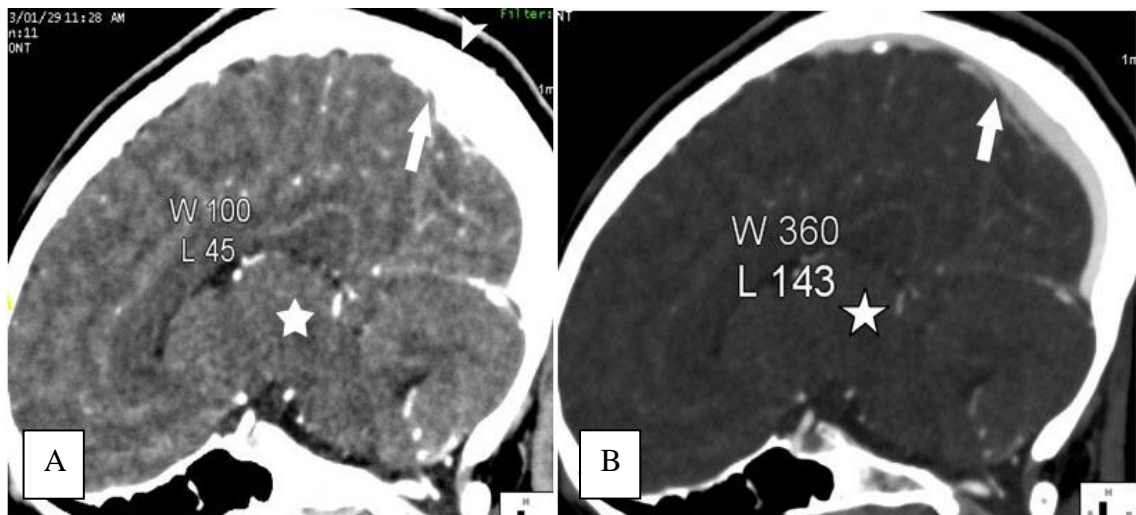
Sagittal reconstruction (A) of injected brain CT with window and level to 100 and 45 respectively. Good parenchymal analysis (star). Incorrect analysis of the sagittal superior sinuse (arrow) and bone (arrowhead) that merge. On B the same slice that with window and level extended to 360 and 143 shows a better differentiation of the vault and the superior sagittal sinuse (arrow). But not optimal analysis of brain parenchyma (star).
